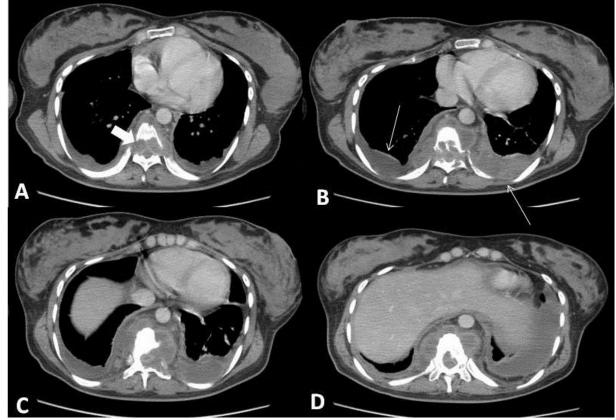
A 30 year old female with atypical spinal tuberculosis. Axial contrast enhanced CT sections of the chest. A-T 8 level, B-T 9 level, C-T 10 level, D-T 11 level, showing destructed vertebrae, para- and pre- vertebral abscesses with epidural abscess (wide arrow). There is also bilateral pleural empyema (arrows). Technique: Multi detector CT scanner (64 slice), mAs 91.7, kV 120, 3.7 mm slice thickness. Porto-venous phase of contrast study using 100 ml Omnipaque (300mg I/ ml).
